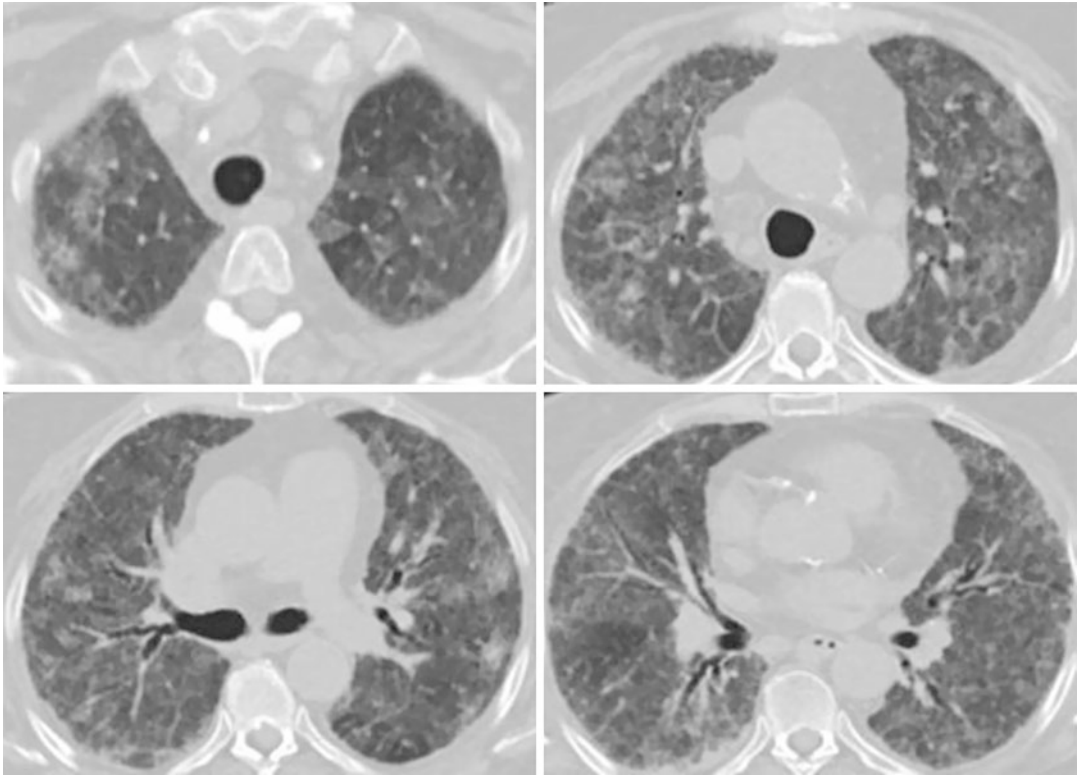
Chest CT findings of nonspecific interstitial pneumonia. Serial sections throughout the chest demonstrate peripheral ground-glass opacities with diffuse
